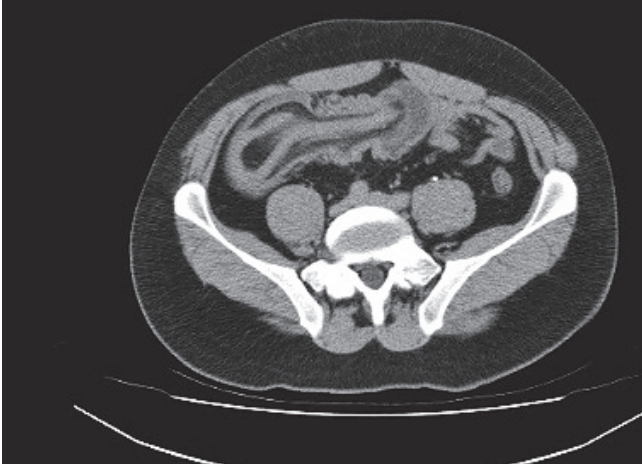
Computed tomography scanning ileoileal intussusception.
